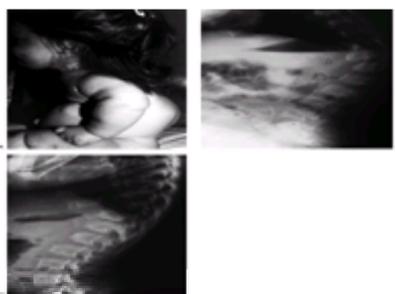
Thoracolumbar kyphosis in a 23-month-old achondroplastic child who has not walked yet. A: It is most pronounced in the sitting position. B: Radiograph at that age shows hypoplasia of L1, with rounding-off of the anterior vertebral body corners. C: At age 5 years, after a period of brace treatment, the shape of L1, as well as the overall kyphosis, has improved.
